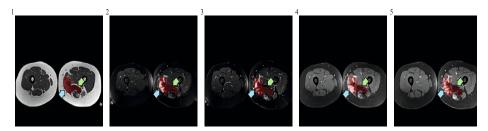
Segmentations on various MRI sequences before and after applying image registration in a desmoid-type fibromatosis case. The arrows are at the same position in each image and point at two details where the (mis)alignment is evident. (1) Original T1-weighted (T1w) MRI; (2) Original T2w-MRI; (3) Registered T2w-MRI; (4) Original T1w post-contrast MRI; (5) Registered T1w post-contrast MRI
